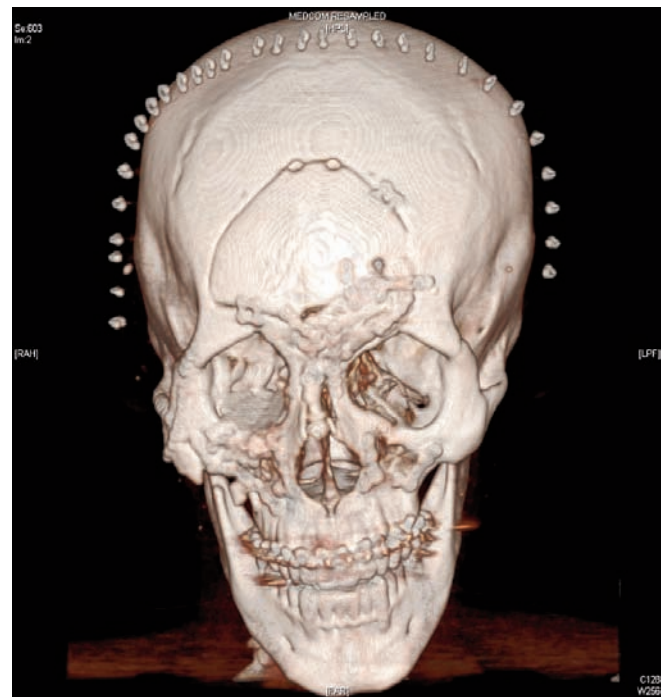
3D CT demonstrating immediate post operative fracture reduction and fixation
